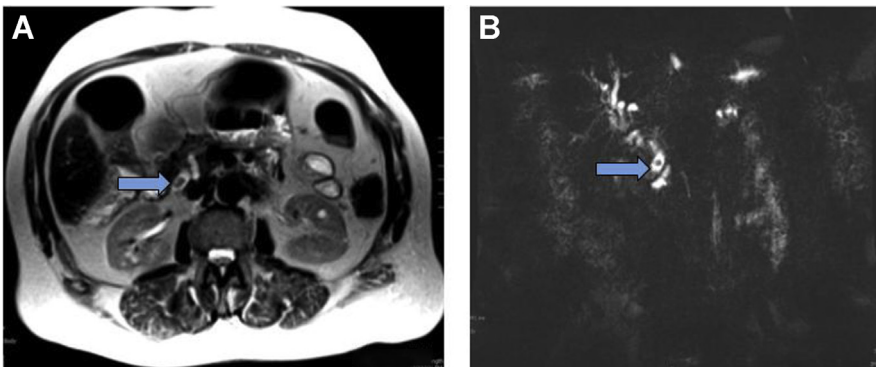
CBD stone on (A) T2-MRI and (B) three-dimensional reconstruction images.
